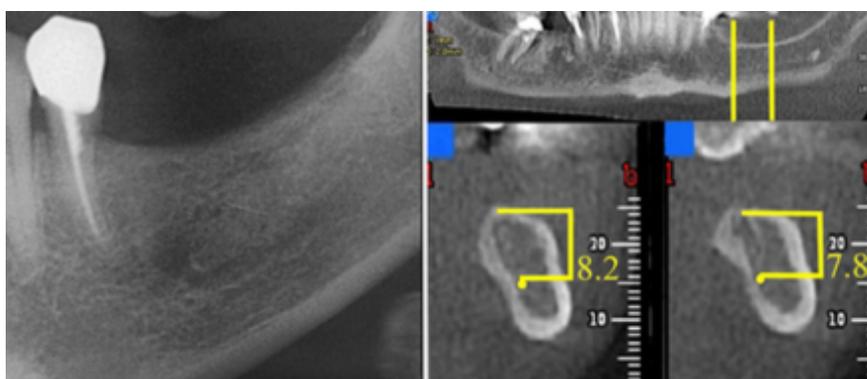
Radiografías del sector posterior de la mandíbula atrofico. (A) Radiografía ortopantomografía (B) CBCT. Imagen sacada del artículo del F. Pieri y cols publicado en el International Journal of Oral and Maxillofacial Surgery.
